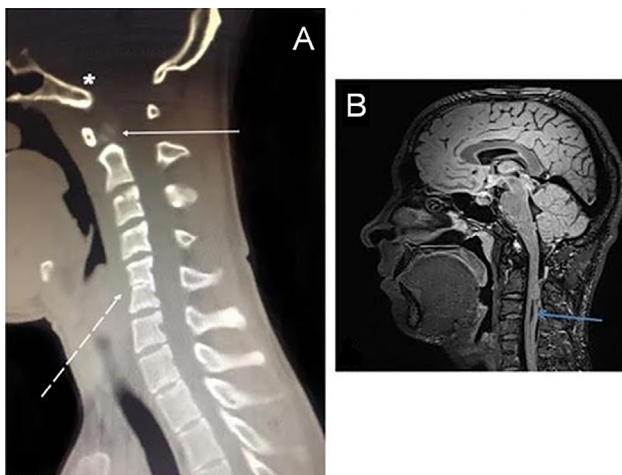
Imaging of the brain and upper level of vertebrae. A) Cervical CT showed the absence of a spinous process of C5, a fusion of the body of C5–C6 vertebrae, hypoplastic dens, and platybasia. B) MRI showed syrinx cavity which extended between C3 to C4 level of the spinal cord.
